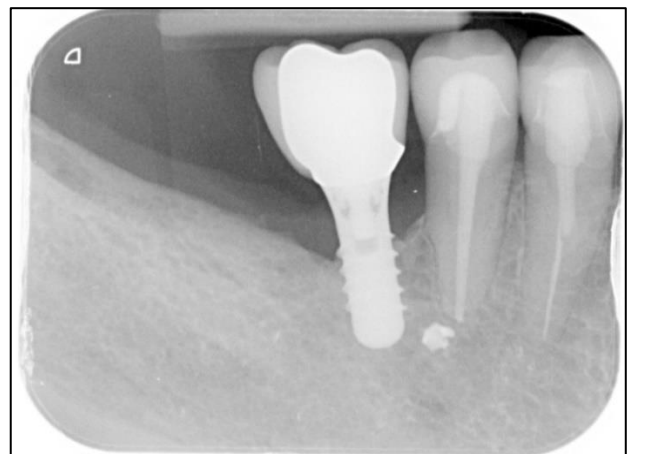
At 5-year follow-up, peri-apical radiograph showed a significant bone gain around implant.
